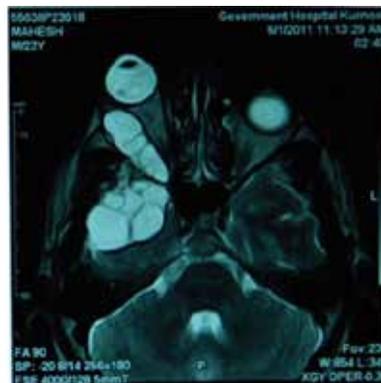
MRI shows multiple cystic lesions in right temporal lobe of brain and right orbit causing proptosis
